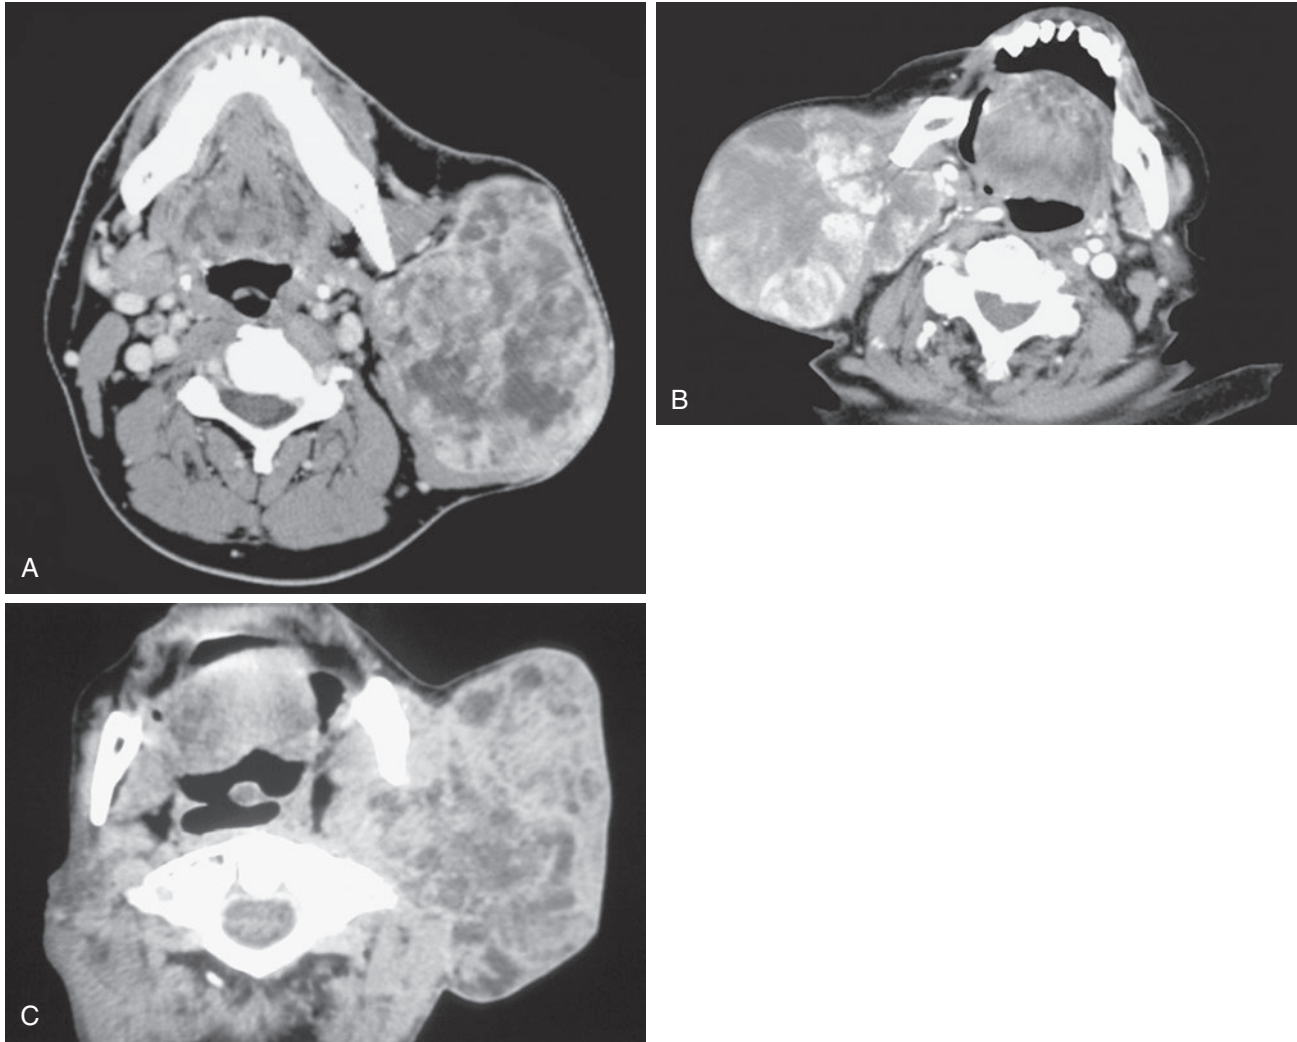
Axial contrast-enhanced CT scans of three different patients.
